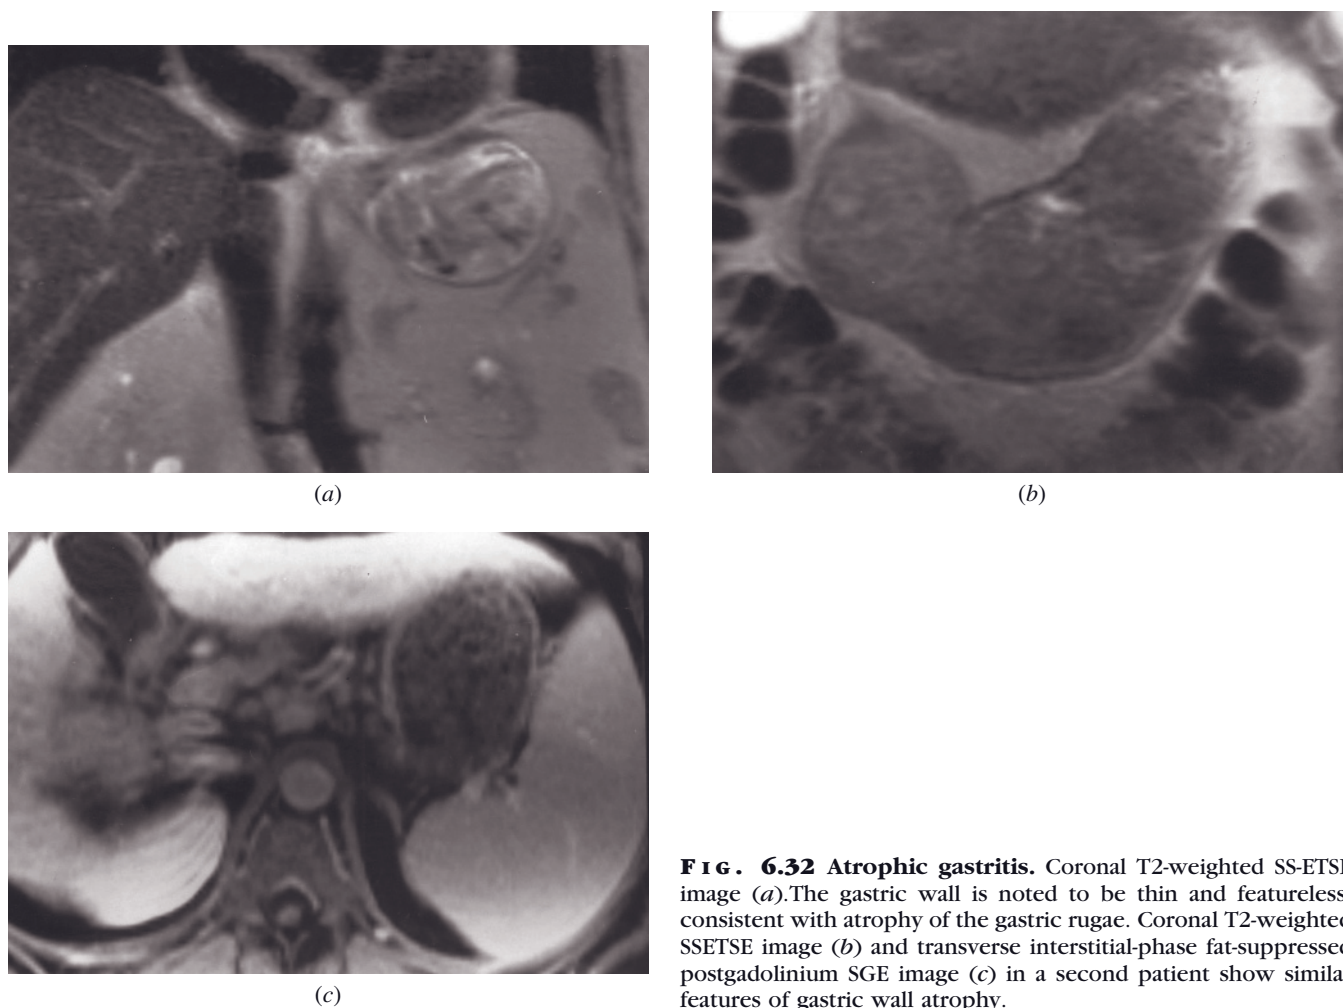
Atrophic gastritis. Coronal T2-weighted SS-ETSE image (a). The gastric wall is noted to be thin and featureless, consistent with atrophy of the gastric rugae. Coronal T2-weighted SSETSE image (b) and transverse interstitial-phase fat-suppressed postgadolinium SGE image (c) in a second patient show similar features of gastric wall atrophy.
